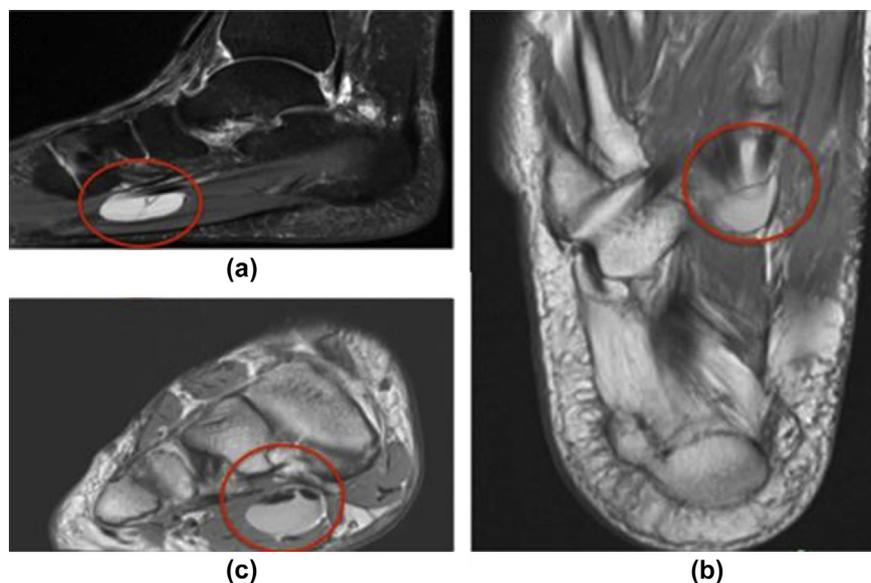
(a) PD FS sagittal, (b) PD axial, (c) PD coronal MRI images show peritendinous fluid signal involving the FHL and FDL tendons at the knot of Henry consistent with tenosynovitis.
